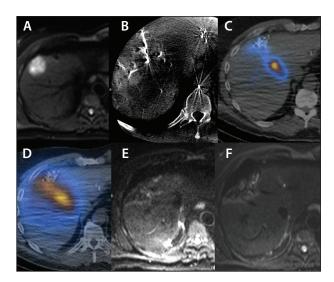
Pretreatment, metastatic colorectal cancer foci exhibited restricted diffusion and measured 3.4 X 4.2 cm within segment 8 (A). CBCT demonstrated that segment 5 and segment 8 hepatic arteries supplied the segment 8 lesion. CBCT also ensured complete coverage of the tumor from the location of the microcatheter where the MAA and future Y-90 was to be administered from (B). Tc99m MAA SPECT/CT confirmed the satisfactory coverage of the targeted tumor within segment 8 and absence of extrahepatic activity (C). Y90 bremsstrahlung SPECT/CT confirmed the complete coverage of the targeted tumor within segment 8 and absence of extrahepatic activity (D). Posttreatment MRI diffusion-weighted images at 6 and 12 months, respectively, demonstrated the absence of mass-like restricted diffusion within the treatment zone (E, F).
